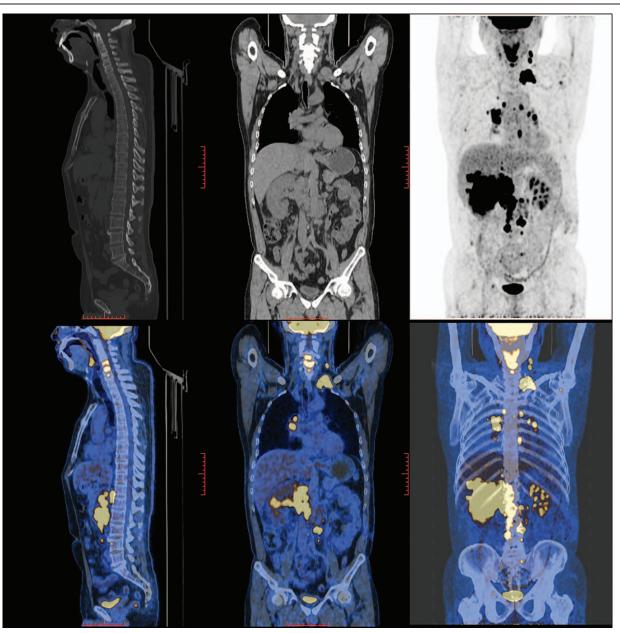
PET-CT using 18F-FDG shows the postoperative residues and multiorgan and lymphonodes metastasis of the tumor 1 month after surgery.
